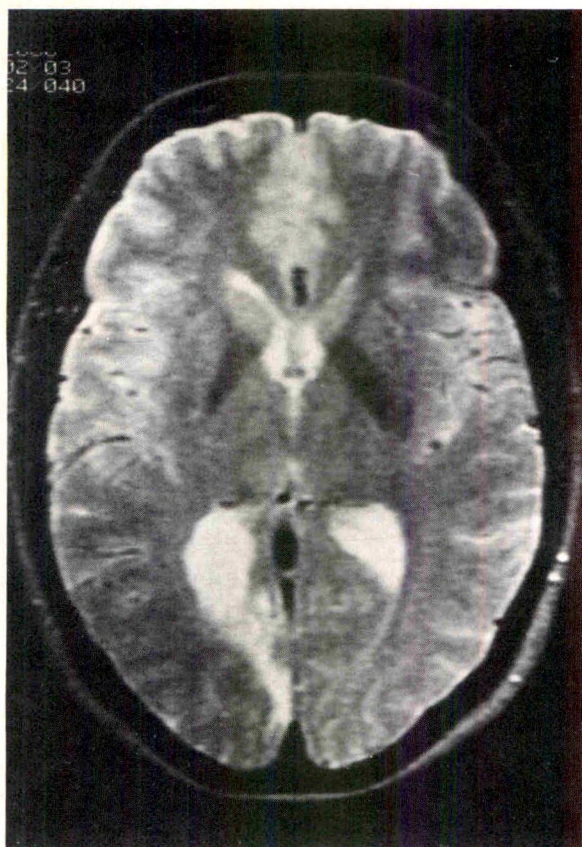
(Bosley and associates) Case 2. T₂-weighted magnetic resonance image with an area of damage compatible with ischemia causing a bright signal involving the periventricular optic radiations, anterior occipital lobe, and posterior temporal lobe on the right. The patient's right is on the left of the figure.
